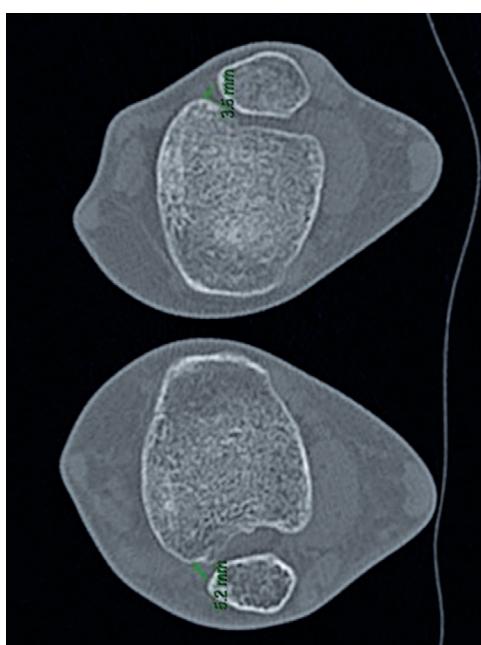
Stress computed tomography with dorsiflexion and external rotation showing widening of the distal tibiofibular space.
